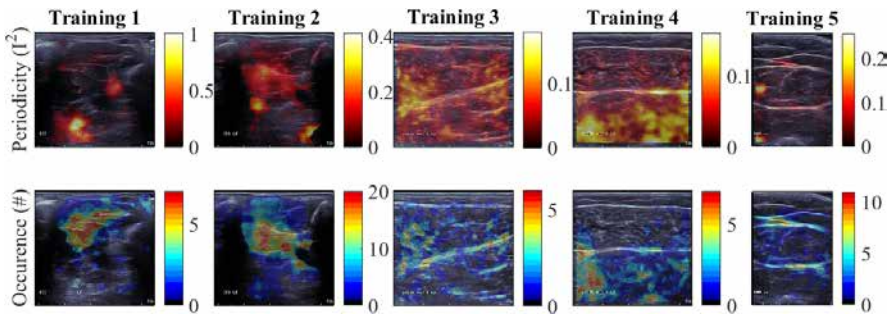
Possible presentation of physiologic parameters to further guide observers in the classification of motion events. Upper row depicts the periodicity (power of spectrum) for five ultrasound image sequences and reveal the locations of vascular pulsation. The lower row depicts the occurrence-map of events and indicates occurrence *i.e.* how often a pixel/region is involved in motion events.
